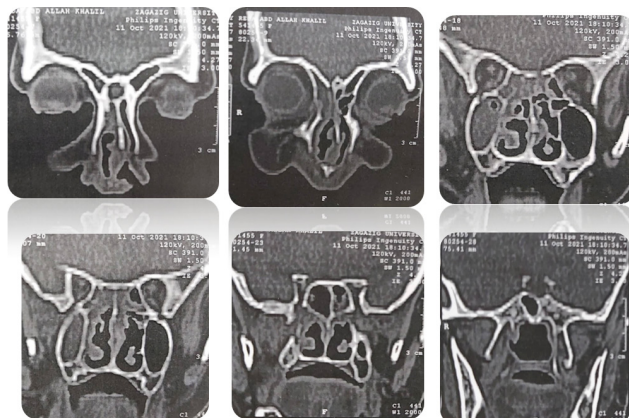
CT scan coronal view shows RT sided sinus opacity affecting maxillary, ethmoidal sinuses
